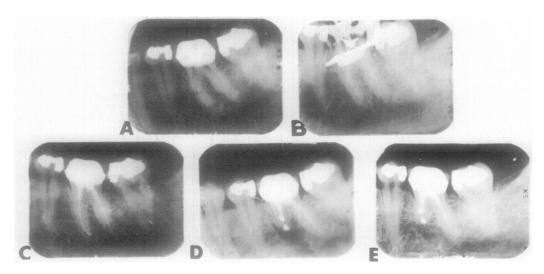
Case 8. Mandibular right first molar of 27-year-old white woman. Root canal treatment was begun by general dentist 2 weeks previously; one Hedström file was broken at midroot in mesiolingual canal. A, Preoperative radiograph showing piece of broken Hedström file in mesiolingual canal. Apical one half of mesiolingual canal could not be negotiated. B, Working radiograph taken during instrumentation. Piece of broken Hedström file is clearly visible in mesiolingual canal. C, Immediate postoperative radiograph taken after obturation with gutta-percha. Patient experiences continuous postoperative pain and there is inability to negotiate apical one half of mesiolingual canal, so surgical intervention is indicated. D, Immediate postoperative surgical radiograph taken after mesial root apicoectomy with removal of Hedström file blockage. Retrograde amalgams were placed in mesiolingual and mesiobuccal apices. E, Recall radiograph 1¹/₉ years later shows asymptomatic tooth with complete apical bony regeneration.
